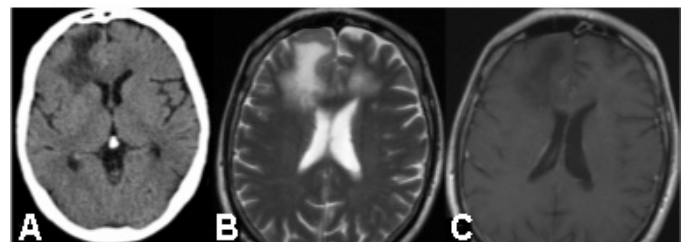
Axial CT, (A), and MRI images of the brain, T2 weighted, (B) and T1 weighted following gadolinium injection, (C). A white matter lesion is noted in the right frontal lobe on CT and bilaterally on MRI, right greater than left. The lesion extends to the subcortical white matter, does not enhance and has a mild mass effect (imaging characteristics typical for progressive multifocal leukoencephalopathy).
